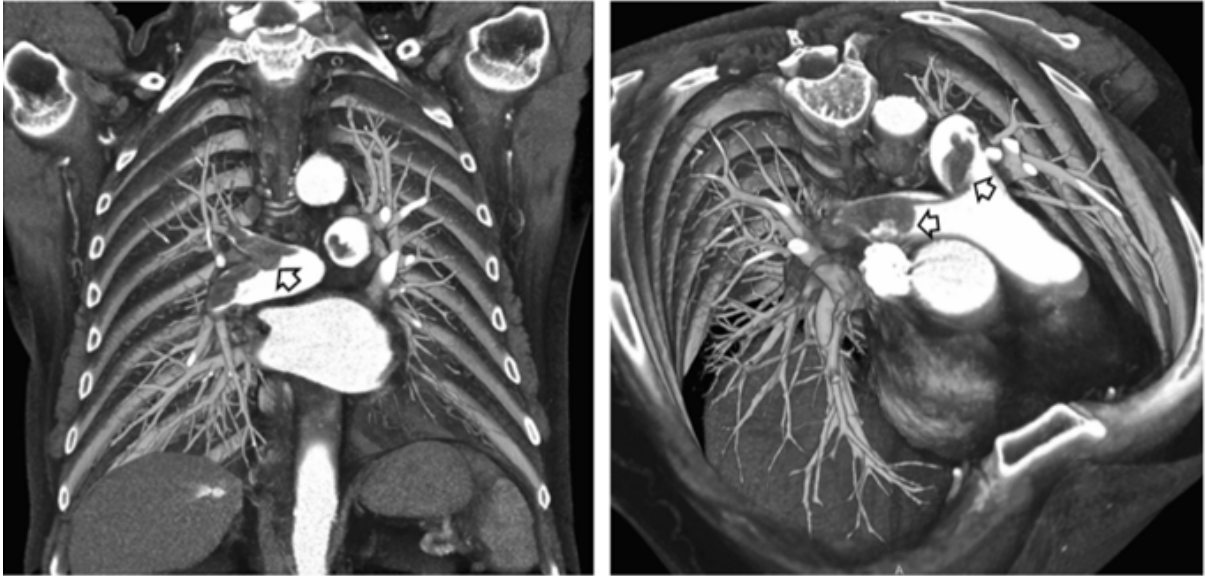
Contrast Material-enhanced 16-detector CT yielded coronal volume renderings in anterocranial and anterior perspective, which allow intuitive visualization of the location and extent of embolus (see arrows) [4].
